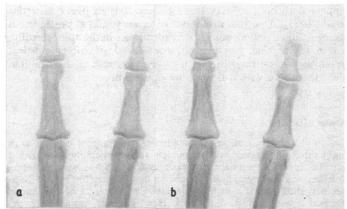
X-ray pictures of index and middle fingers (left) in 1966 when she had gross osteitis fibrosa with subperiosteal erosions and erosion of phalangeal tufts, and (right) in 1972 when no signs of osteitis fibrosa can be seen.
